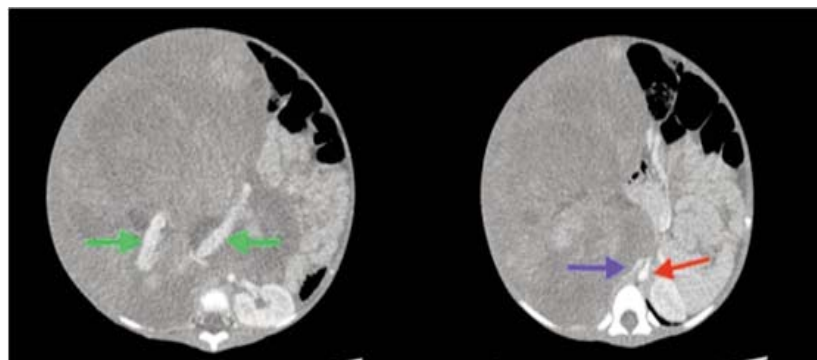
Left: Contrast enhanced CT showing a huge heterogeneously enhancing right hemi-abdominal mass extending across the midline with residual enhancing right renal parenchyma (arrows). It is encasing the left renal vessels at renal hilum. Right: IVC (red arrow) and aorta (green arrow) are compressed.
